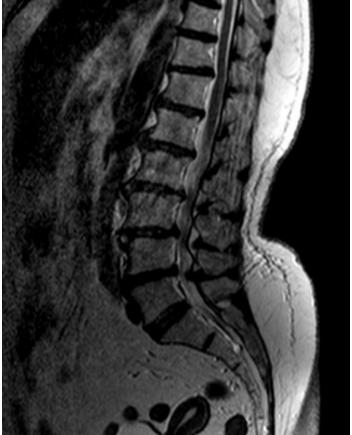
Sagital lomber MRI view of same patient
